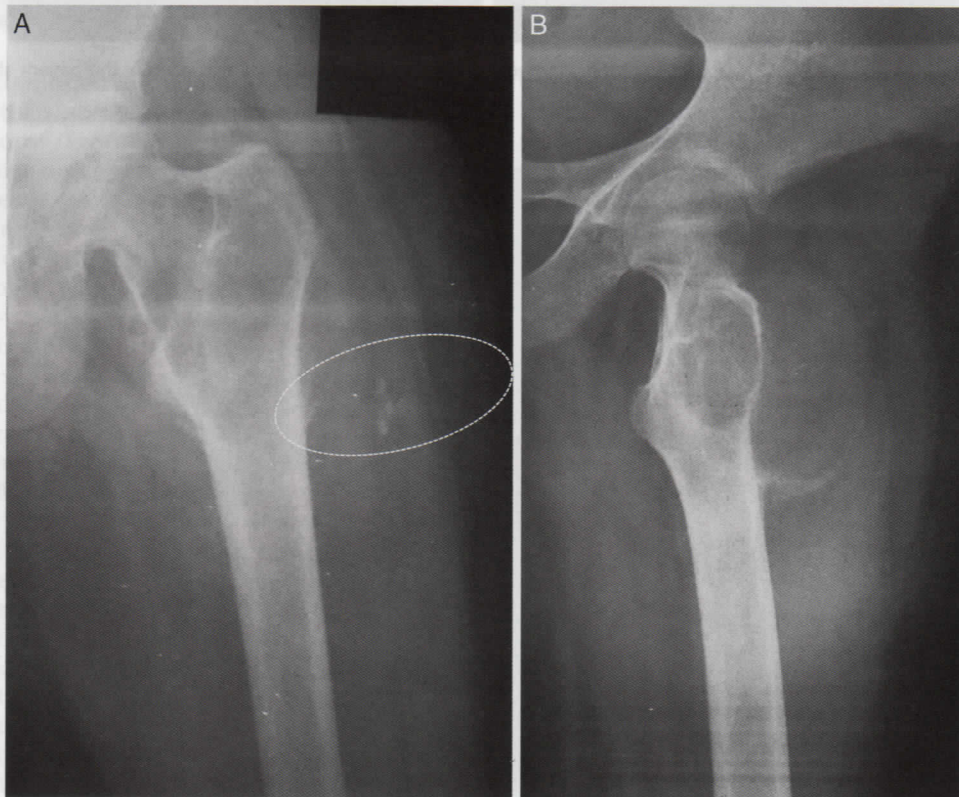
Anteroposterior (A) and lateral (B) radiographs of the affected hip after 6 weeks of conservative treatment for the pathologic fracture. Notice the outline of the secondary lesion originating from the proximal third of the femur and the first signs of primary mineralization of the lesion along the track of the biopsy (dotted line).
